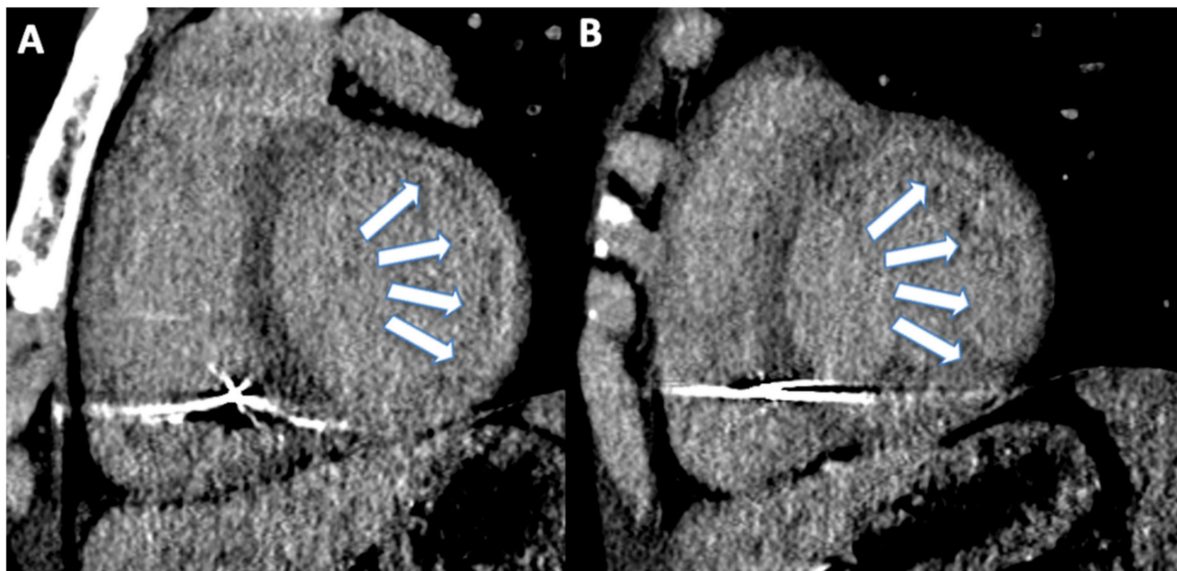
(A) 23 year old male patient with history of cardiac arrest. After the implantation of implantable cardioverter defibrillator, the patient acquired cardiac computed tomography angiography for the assessment of late iodine enhancement. Late iodine enhancement reconstructed on short axis showed intramyocardial late iodine enhancement on anterior, lateral, and inferior wall of basal (arrows, (A)) and mid-ventricular (arrows, (B)) left ventricle.
